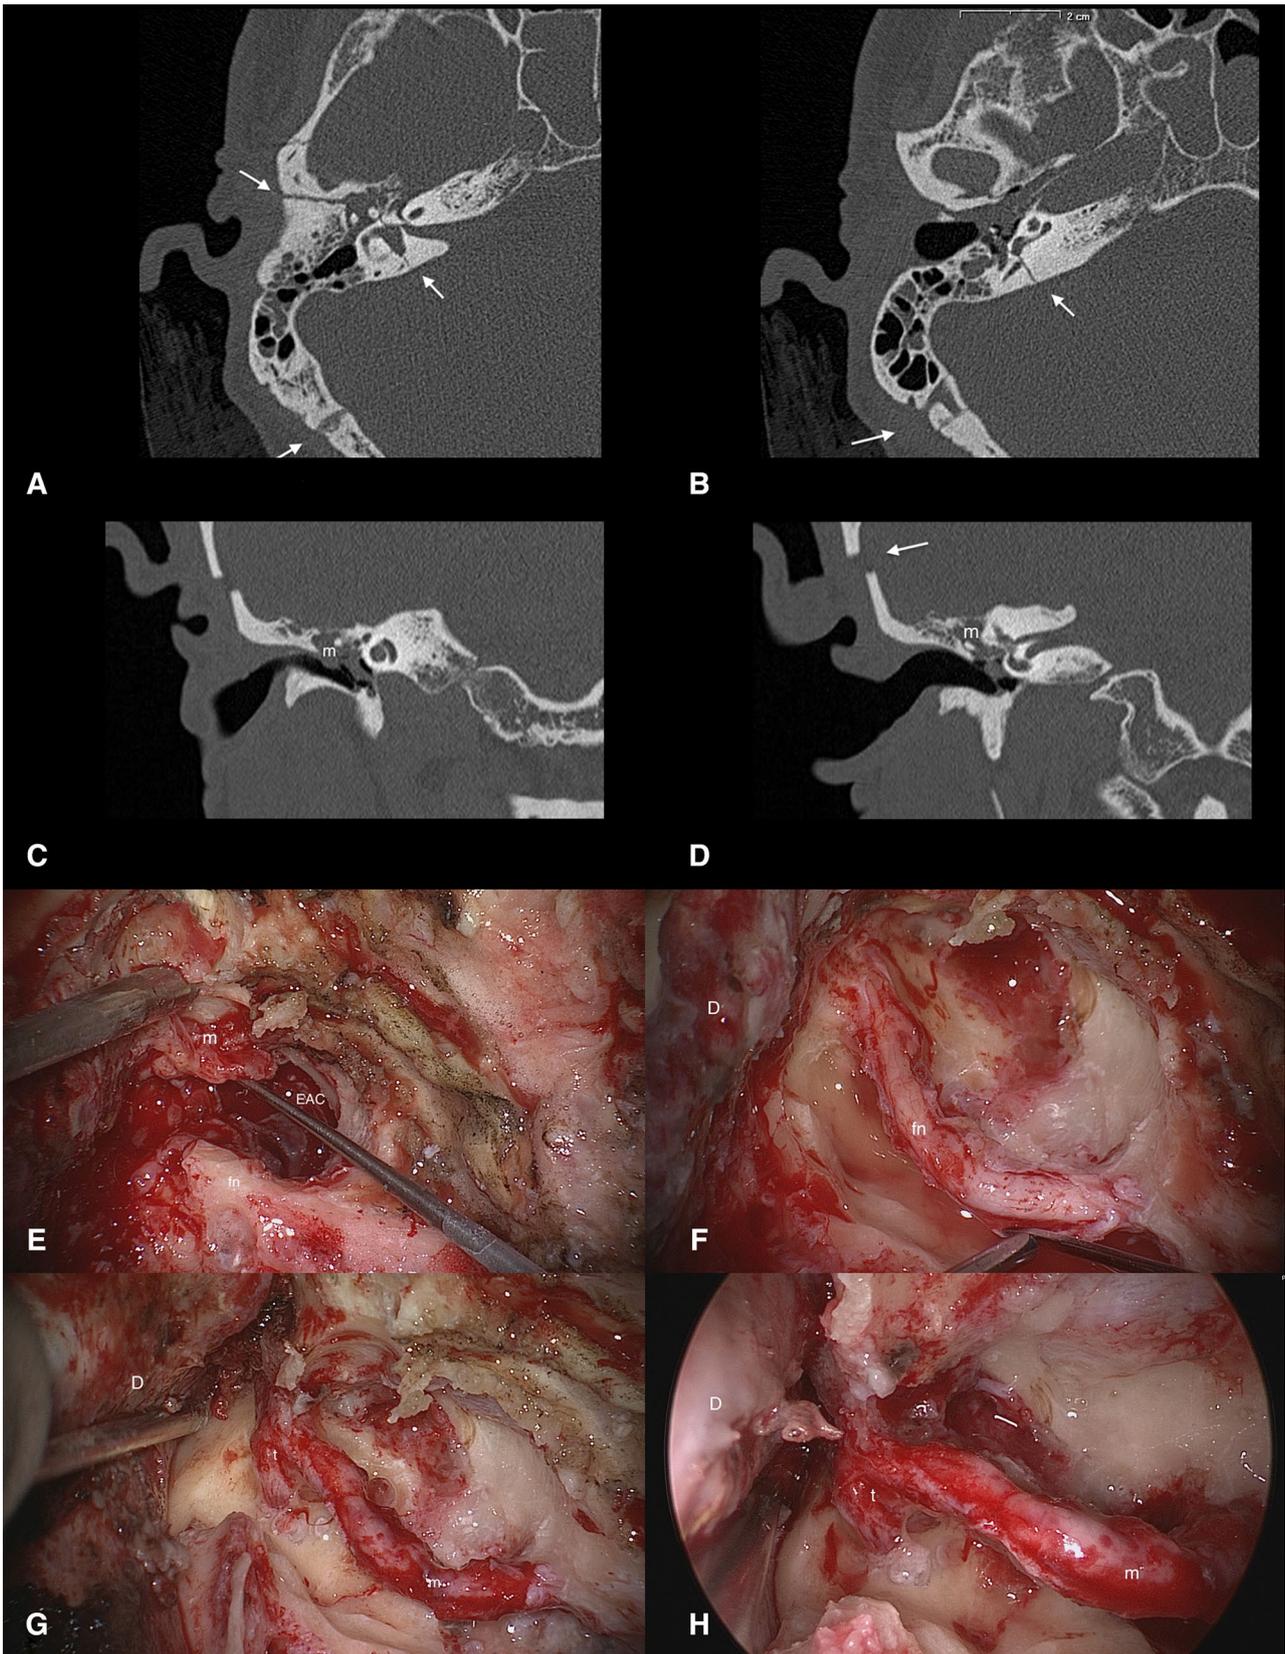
Preoperative CT scan and Facial nerve decompression. Transmastoid-transotic approach. Right ear. a, b Fracture lines (white arrows) passing through the temporal squama, the mastoid and crossing the semicircular canals. c, d Fracture line across the temporal squama (white arrow) and meningocele occupying the tympanic cavity. *m* meningocele. e The meningocele (*m*) protruding into the external auditory canal (EAC). *fn* facial nerve. f After a canal-wall-down mastoidectomy, labyrinthectomy and drilling of the cochlea, the third portion of the facial nerve was skeletonized (*fn*). The bone canal was completely opened and the perineural sheath removed. Dehiscent dura of the middle cranial fossa (D). g After a temporal craniotomy, decompression of the tympanic portion of the facial nerve (*t*). *m* mastoid portion. Dehiscent dura of the middle cranial fossa (D). h Endoscopic view of the facial nerve completely decompressed in its tympanic (*t*) and mastoid (*m*) portions. Dehiscent dura of the middle cranial fossa (D)
